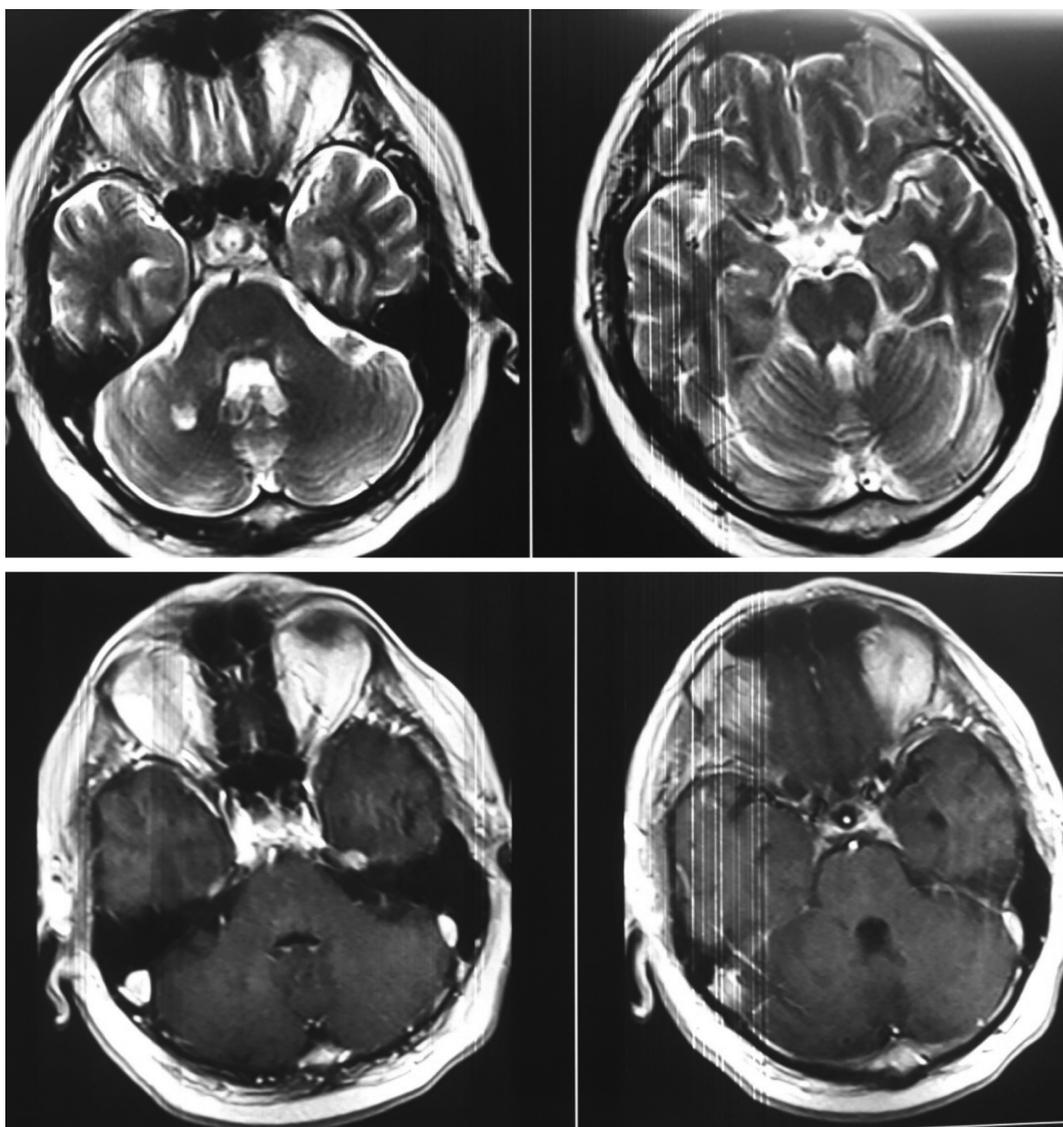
Imaging improvement after steroid therapy (about 11 month after first MRI).
